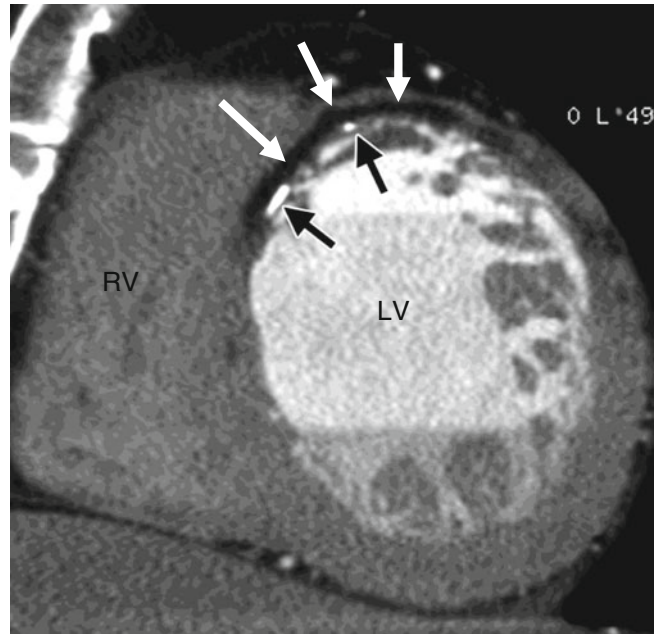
Fatty infiltration of a healed myocardial infarct in a 57-year-old man. This short-axis contrast-enhanced CT image shows subendocardial fat (*white arrows*) and small calcifications (*black arrows*) in the anterior wall of the left ventricle. *LV* left ventricle, *RV* right ventricle (Reproduced with kind permission of Radiological Society of North America, Oak Brook, IL from Kimura et al. [3])
